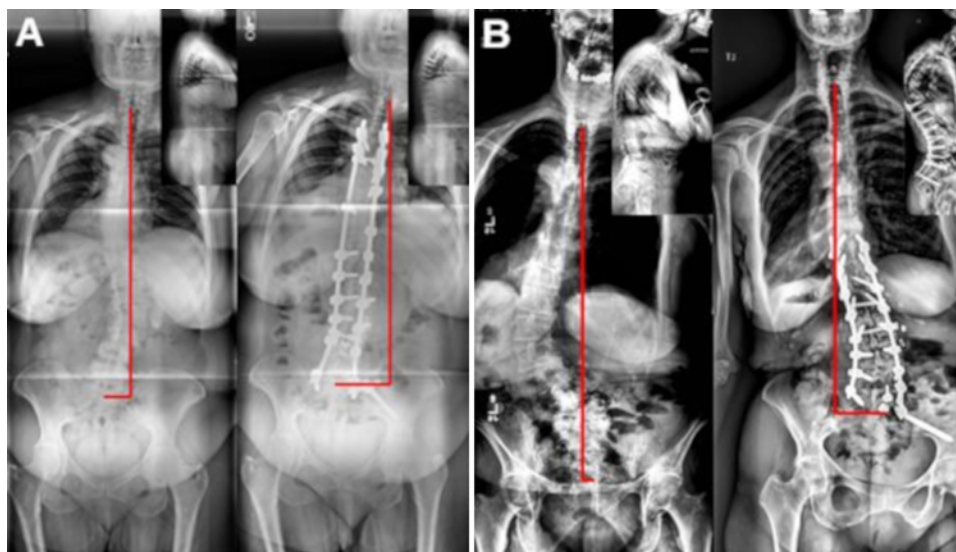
Standing scoliosis radiographs of 2 patients included this study, demonstrating postoperative global coronal deterioration ≥ 1 cm. Index operations involved long posterior instrumented fusion extending from the sacropelvis to UT spine (A) and LT spine (B). The measured magnitude of worsening GCM was approximately 5 cm in the UT spine and 7 cm in the LT spine. Figure is available in color online only.
